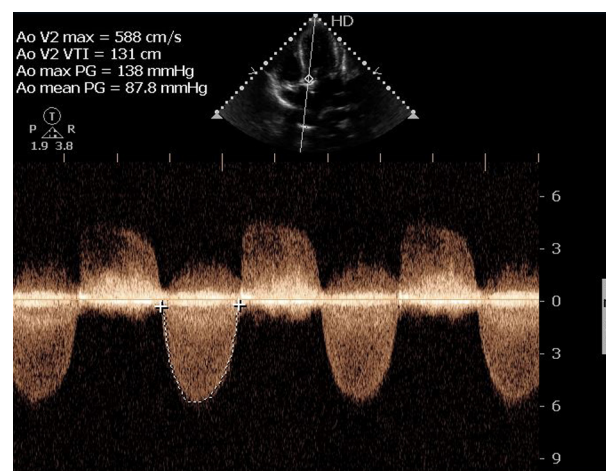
Continuous Doppler wave across the aortic valve showing critical aortic stenosis and mild aortic regurgitation.
